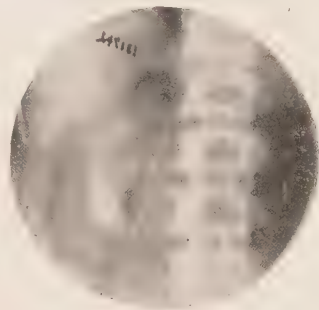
Roentgenogram showing large number of gall-stones in the gall-bladder (Carman):
